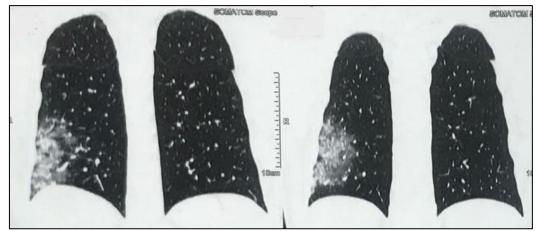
HRCT thorax showing peripheral, pleural based opacity with GGO and consolidation with line of demarcation between normal and abnormal lung in lower lobe right lung
